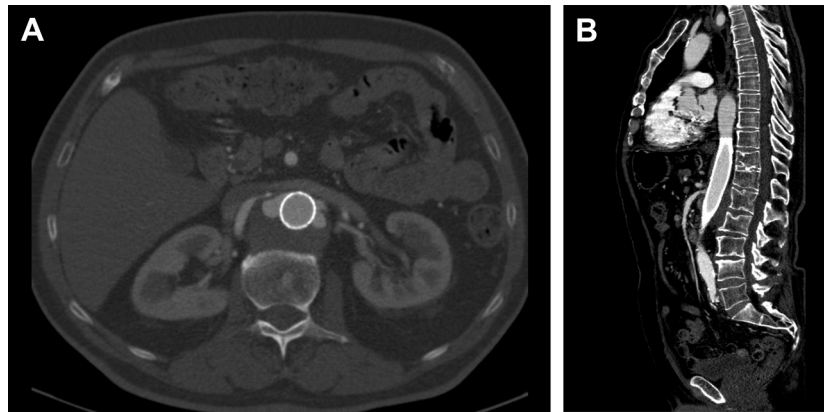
A and B, A computed tomography (CT) angiography 18 months after surgery shows a stable, mostly thrombosed, aneurysm with patent visceral arteries.
